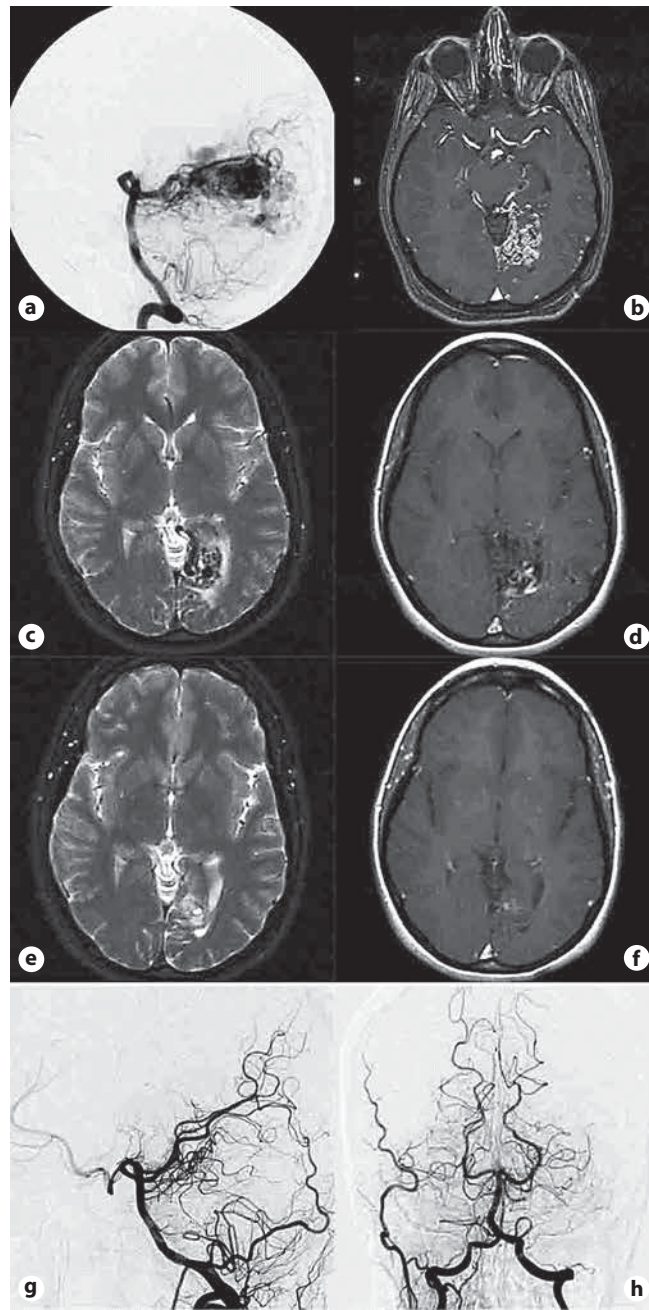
a Lateral vertebral artery angiogram documenting an AVM in the left occipital lobe. b Axial T₁-weighted contrast-enhanced MR image showing a left occipital AVM. c, d Axial T₂- and T₁-weighted contrast-enhanced MR images obtained 1 year after radiosurgery showing a reduction of AVM nidus. e, f Axial T₂- and T₁-weighted contrast-enhanced MR images obtained 2 years after SRS showing the absence of a nidus. g, h Lateral and anteroposterior vertebral artery angiograms obtained 2 years after SRS showing the absence of a nidus and early venous drainage.
